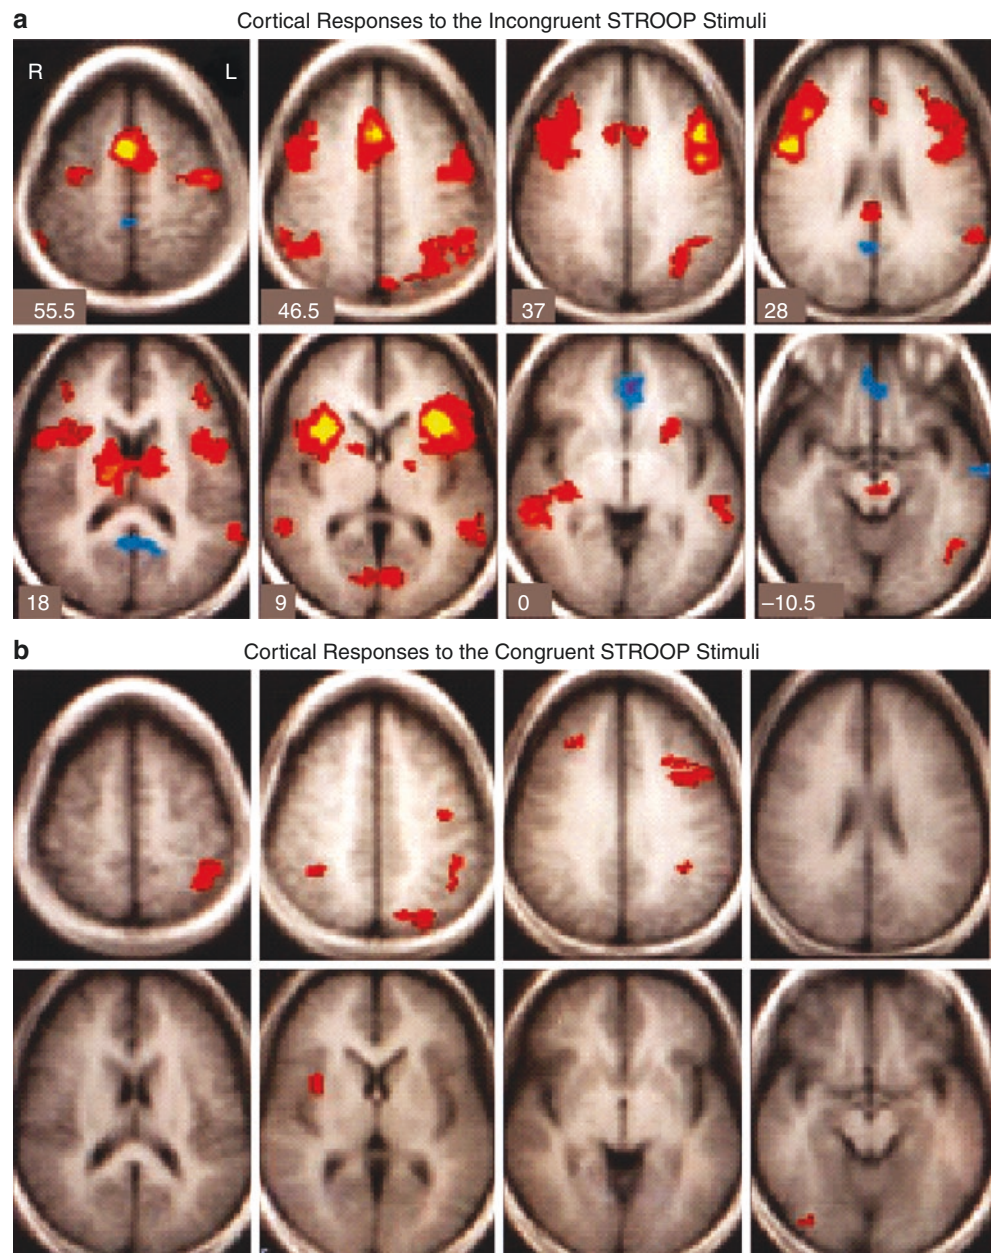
The classical Stroop color word interference task. In congruent cases, the color of the ink matches the color of the word. In incongruent cases, the color of the ink is different from the color of the word. The words are presented sequentially to subjects who respond by indicating the color of the ink for each word. (Reprinted with permission from Leung H-C, Skudlarski P, Gatenby JC, Peterson BS, Gore JC. An event-related functional MRI study of the Stroop color word interference task. *Cereb Cortex*. 2000;10:552–560. Oxford University Press [92])
